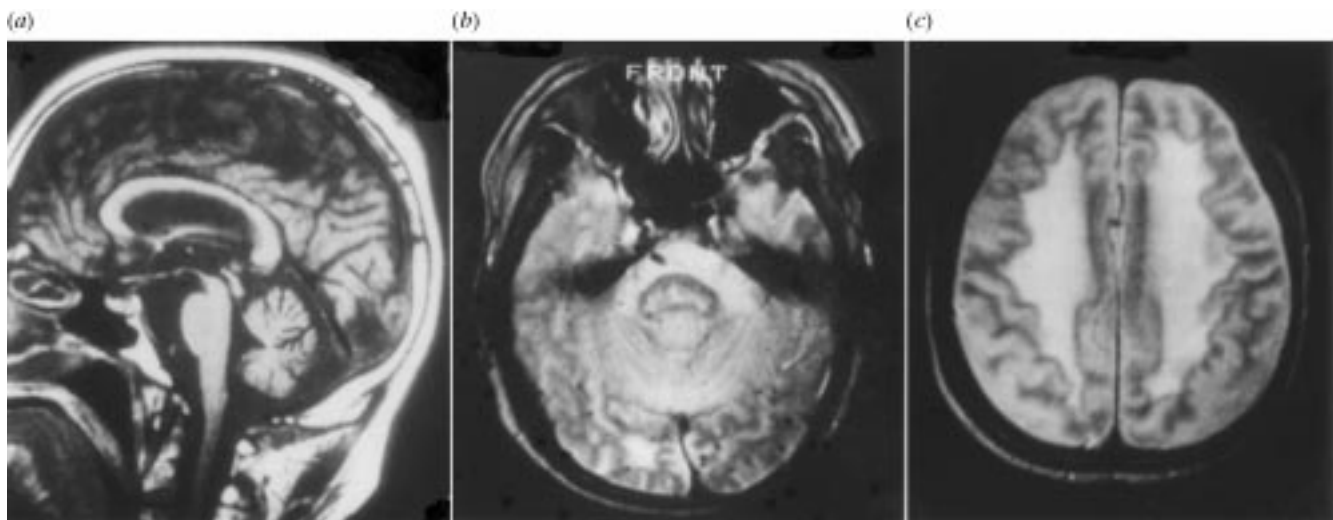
MRI (1.5 T) findings in an adult onset DRPLA patient (54-year-old male). (a) The T1-weighted (TR/TE 400/15) midsagittal MRI image reveals proportional but 'small in size' brainstem and cerebellum with VIth ventricular dilatation. (b) The T2-weighted (TR/TE 3000/45) axial MRI image reveals diffuse high-intensity signals in the middle pontine region. (c) The T2-weighted (TR/TE 3000/45) axial MRI image reveals symmetrical, diffuse high-intensity signals in the periventricular white matter.
